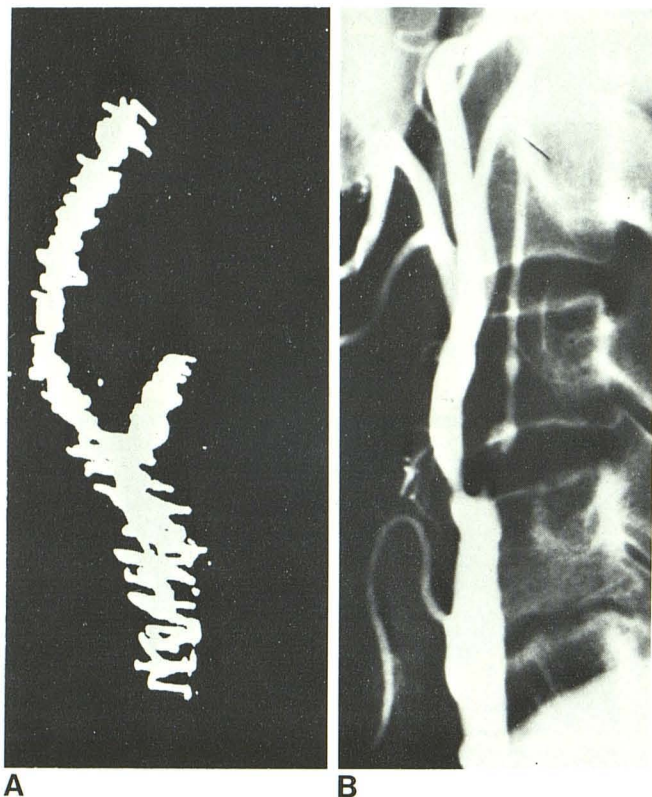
Severe stenosis mistaken for occlusion. False-positive diagnosis of occlusion in 66-year-old woman after 6 months of recurrent syncopal episodes. A, Doppler examination. No flow signals in area of left internal carotid. Left posterior orbital flow signals (not shown) were of low amplitude but normal direction. B, Arteriography 1 day later. Sluggish flow in small caliber internal carotid lumen. Flow velocity not sufficient to produce detectable Doppler shift. Nonhemodynamically significant stenosis (65% decrease in area) in external carotid was correctly diagnosed by Doppler examination.
